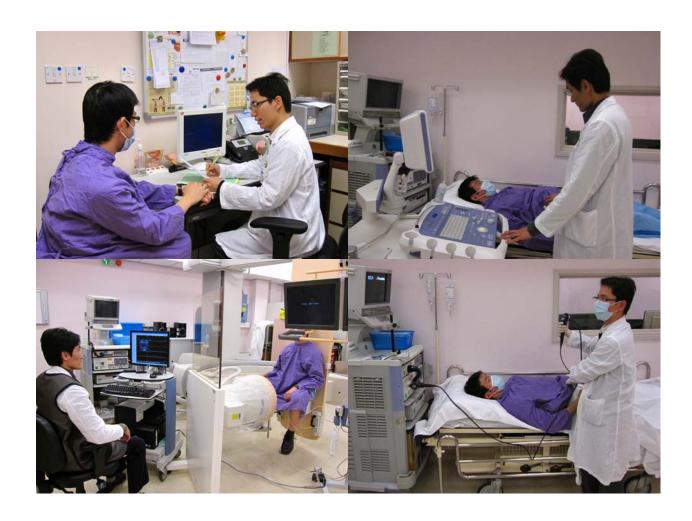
a-d Special ketamine clinic setting in PMH: consultation and counselling (a), ultrasound examination (b), urodynamic study (c) and flexible cystoscopy (d)
